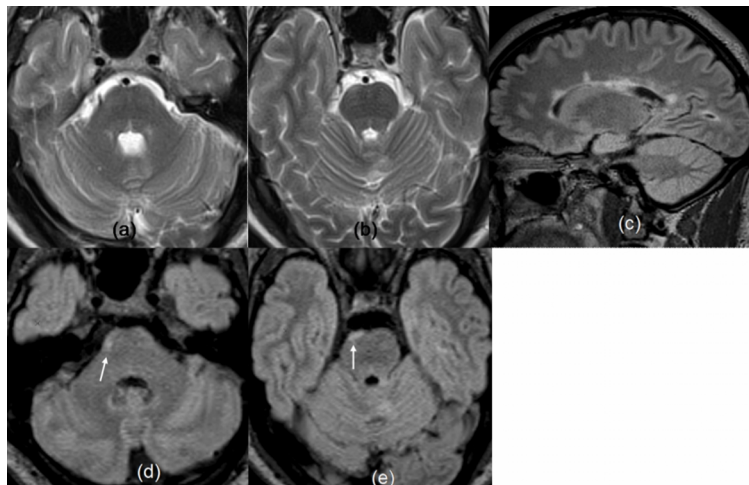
Young patient clinically suspected of MS. T2 axials (a,b) show no convincing brainstem abnormality. 3D FLAIR sagittal reconstruction (c) shows periventricular white matter lesions, although no juxtacortical lesions were present. 3D FLAIR axial reconstructions (d,e) through brainstem show further lesions (arrows) on the peripheral aspects of brainstem, not reliably seen on T2 axials
